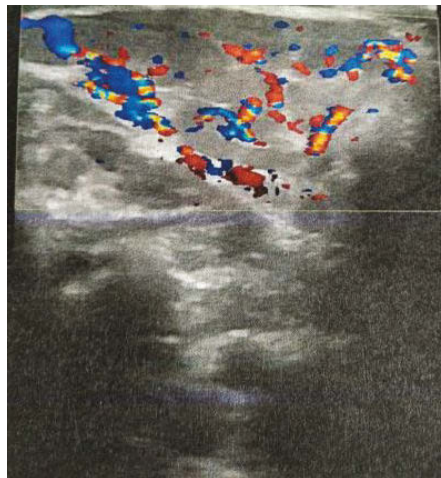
Color Doppler ultrasonographic evaluation revealed the increased blood supply to the lobular lesion, with well-demarcated boundaries and increased flow velocity.
